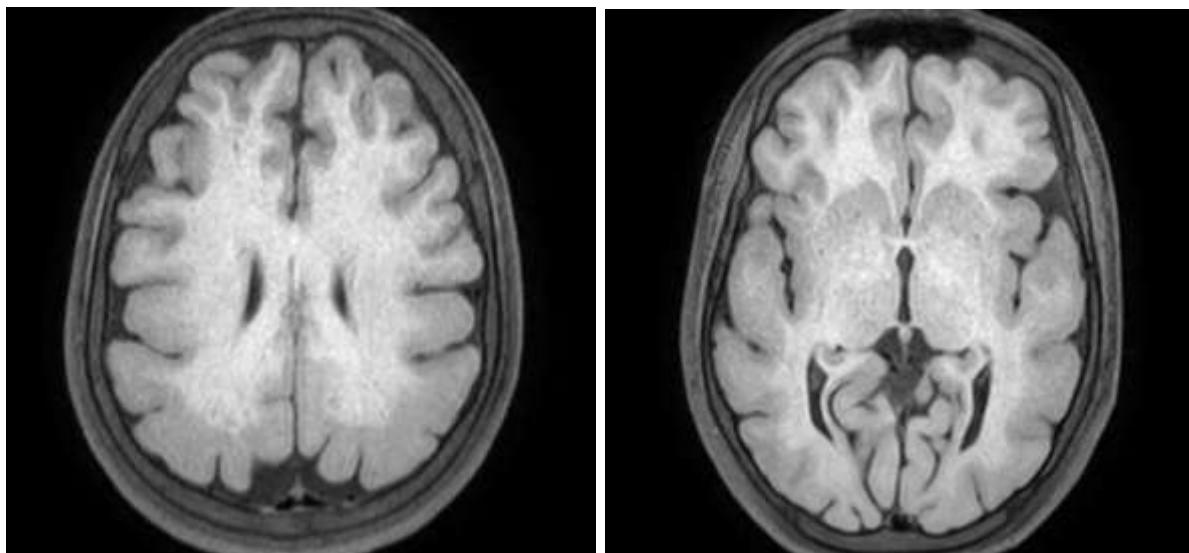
Axial 3D T1-weighted MR images show marked cortical thickening of predominantly bilateral parietal (black triangles) and posterior temporal (black arrow) lobes associated with broad gyri and shallow sulci, blurred grey white matter differentiation and smooth cortical surface
